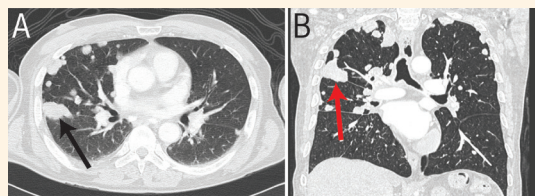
High resolution computed tomography scans of the chest of a 58-year-old male patient (case two) in (A) axial and (B) coronal views showing bilateral pulmonary nodules (black and red arrows) and central calcification in the right upper lobe nodule (red arrow).
